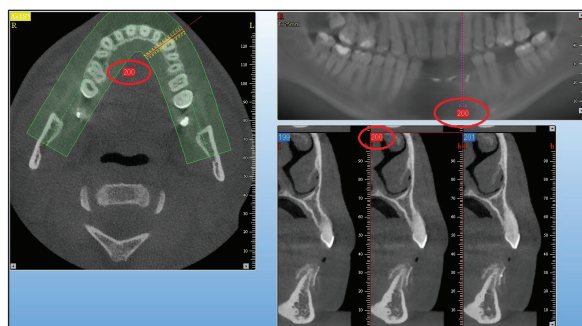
CBCT scan – vertical section number selected.
